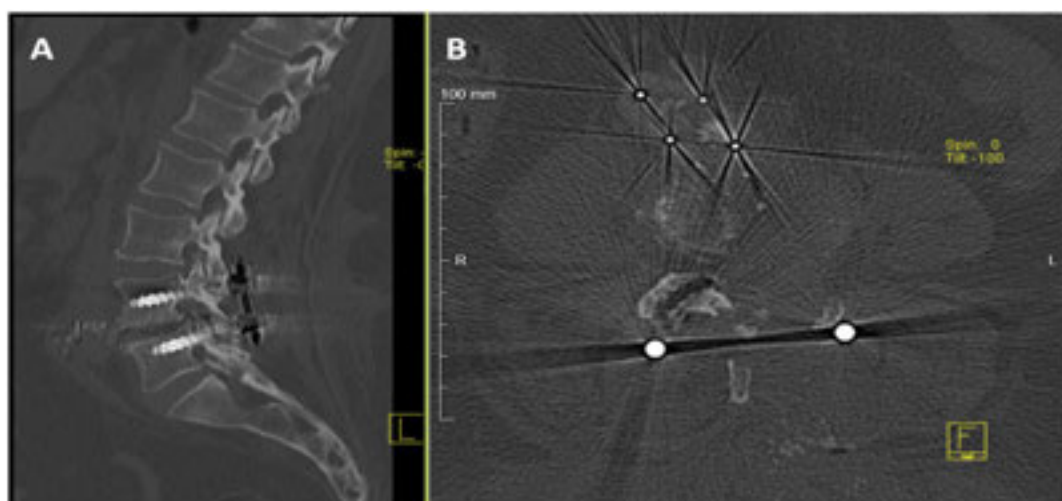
A and B. CT scan showing the OLIF cage situated into retroperitoneal space.
